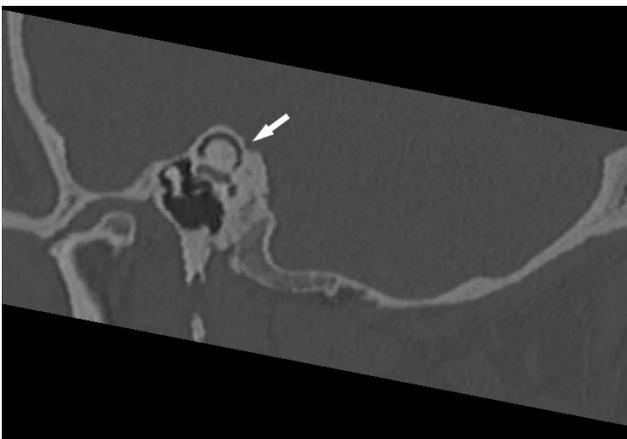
A reformatted CT image of a non-dehiscent left SSC on the plane of Poschl shows the continuity of the bone over the left membranous SSC (arrow).
